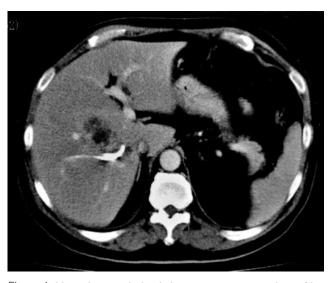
Liver abscess drained via a percutaneous catheter (day 7) inserted under ultrasound guidance
